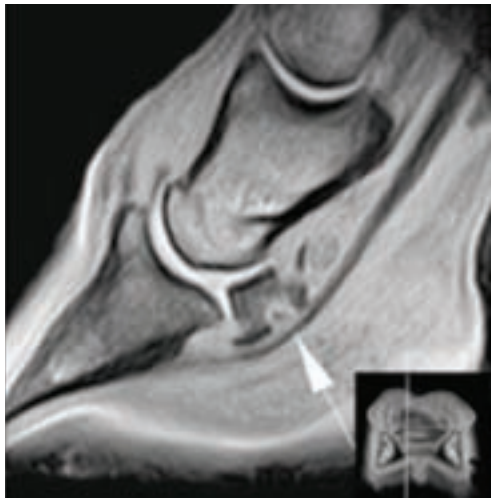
(Sagittal T2* weighted image of the foot) The white arrow denotes a focal area of necrotic bone within the navicular bone. The penetrating tract through the sole and deep digital flexor tendon could also be identified on MRI.
